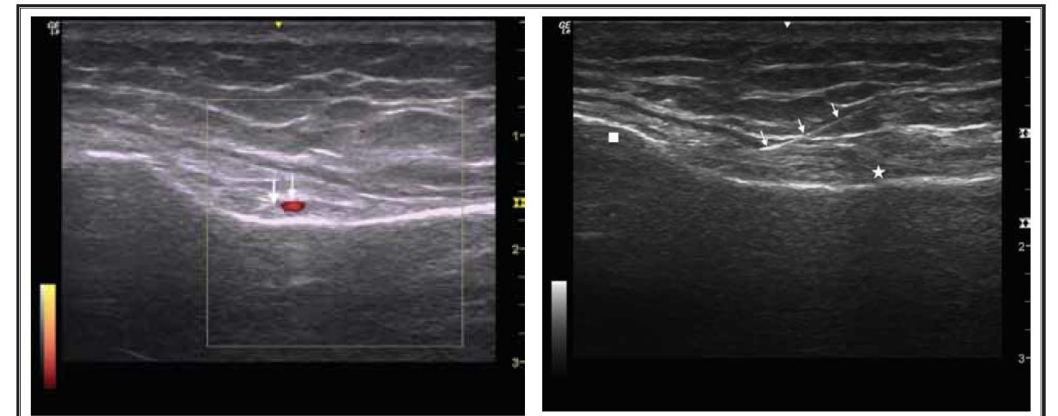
(a) Longitudinal ultrasound image of the knee at the level of the tibial medial epicondyle. Inferior medial genicular nerve (thick arrow) and the corresponding artery (thin arrow) were visualized using power doppler. (b) The needle (arrows) was placed to the bony cortex at the midpoint between the peak of the tibial medial epicondyle (square) and the initial fibers inserting in the tibia of the medial collateral ligament (star) for inferior medial genicular nerve.
